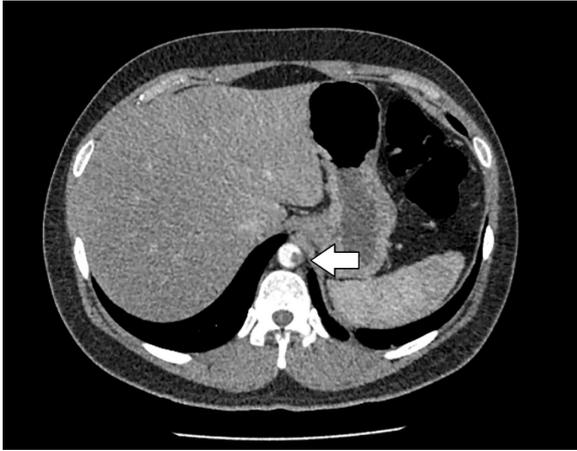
Abdominal computed tomography scan revealing sparse luminal peripheral thrombi in the descending thoracic aorta (arrow).
